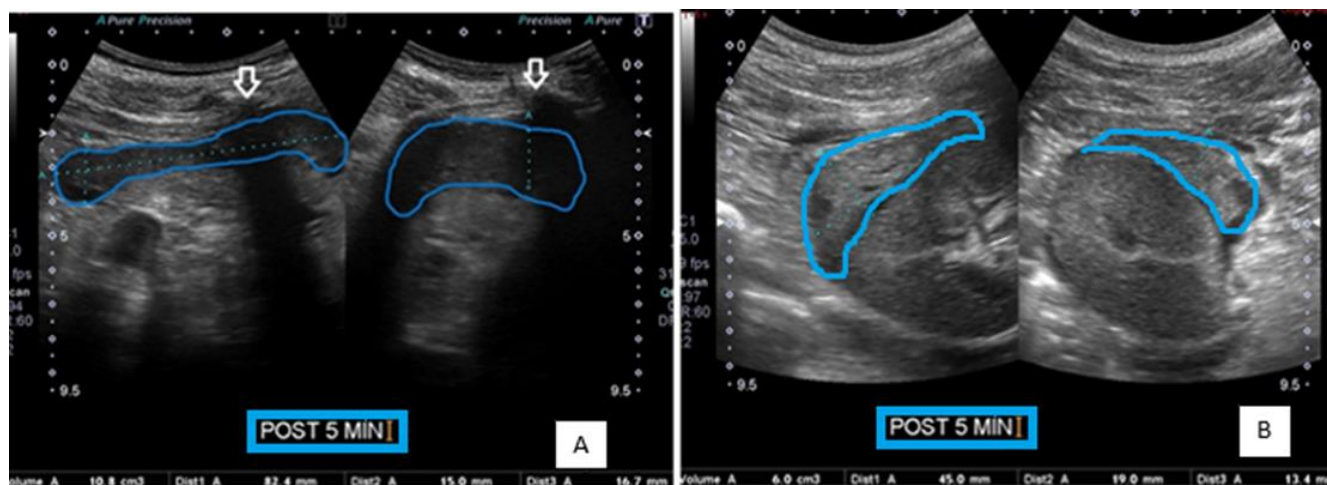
(A) Native kidney ultrasound with small hypoechoic hematoma (10ml) near upper pole cortex. (B). Native kidney ultrasound with isoechoic peri-nephric hematoma (6ml). Arrow points out the rib shadow.
